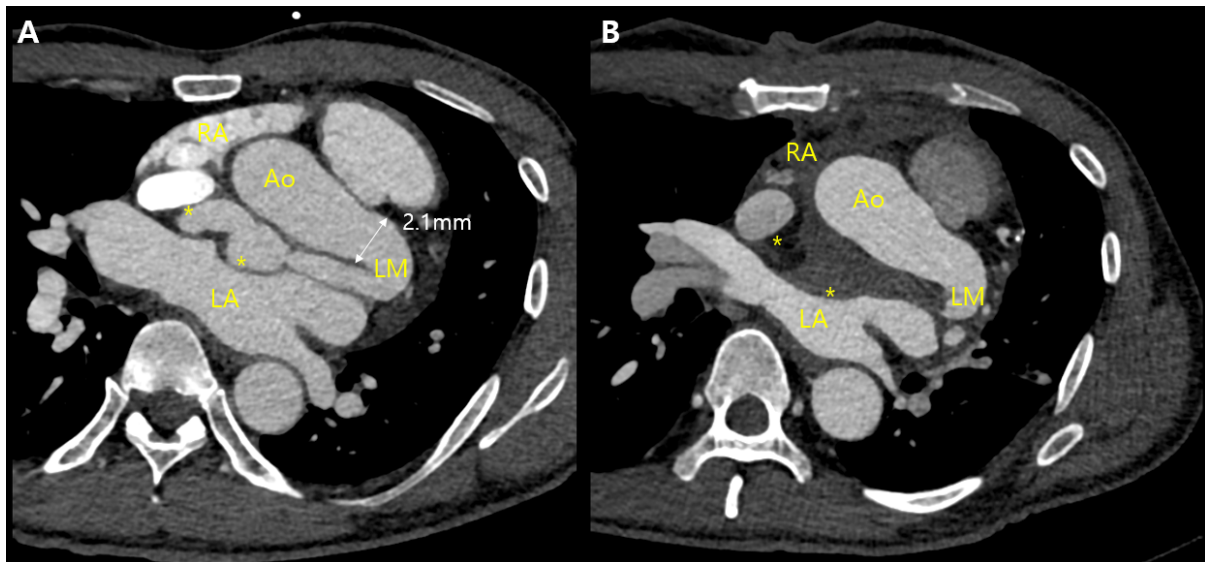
Coronary computed tomography angiography images showing invisible communication of fistulas after surgery. (A) Preoperative and (B) postoperative images.
